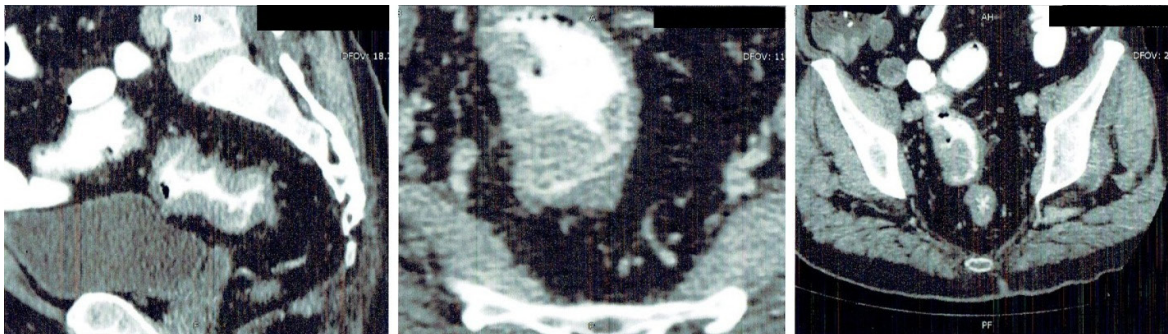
Pre-operative contrast enhanced CT scan of abdomen depicting a circumferential asymmetric, enhancing wall thickening/growth over a length of approximately 5 cm and 12 cm proximal to the anal verge seen involving proximal and middle part of rectum with significant luminal narrowing
